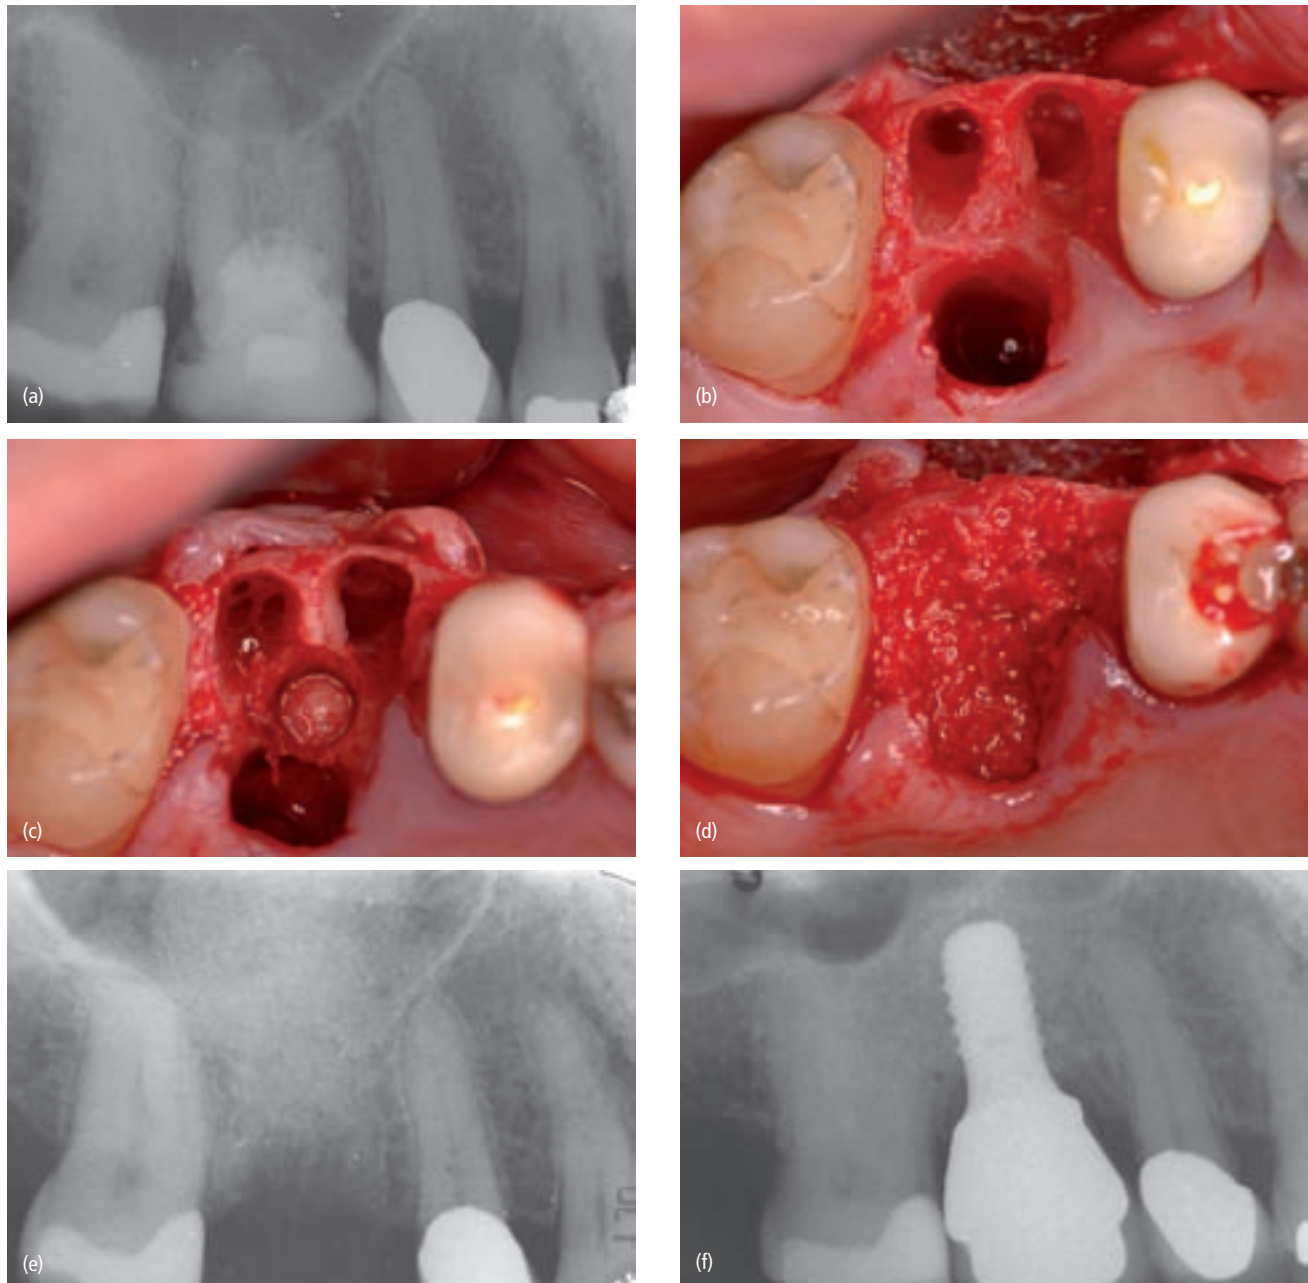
(a) Pretreatment radiograph of the maxillary right first molar, which is not treatable. (b) Occlusal view after removal of the first molar. (c) A trephine has been used at the furcation bone to allow for future site development. The osteotomes have been used to implore the bone core at the prior furcation bone septum. (d) The site is grafted with mineralized freeze-dried bone. (e) Radiograph taken at the time of elevation suggesting favorable elevation of the inferior sinus wall. (f) This radiograph was exposed at 1 year after loading of the implant. The area appears to have a favorable outcome to care.
